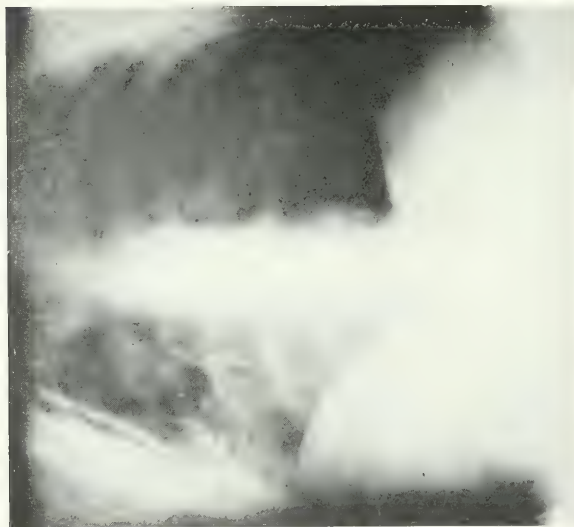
X-ray showing the healed diaphragm somewhat caught up to the chest wall at the operation wound.
